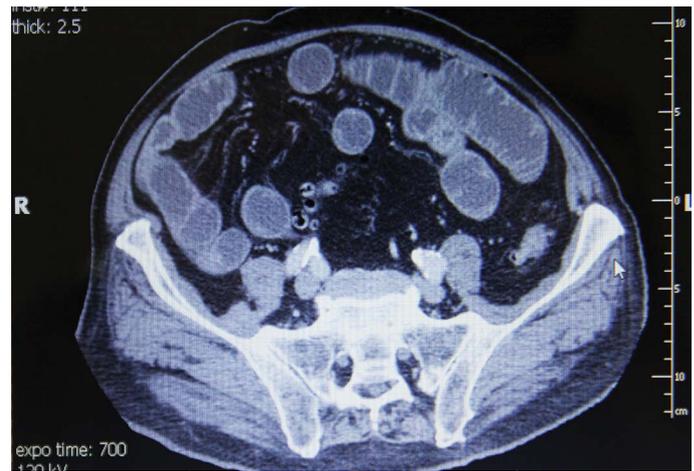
Abdominal CT images showing small intestine loops completely filled with fluid content.
